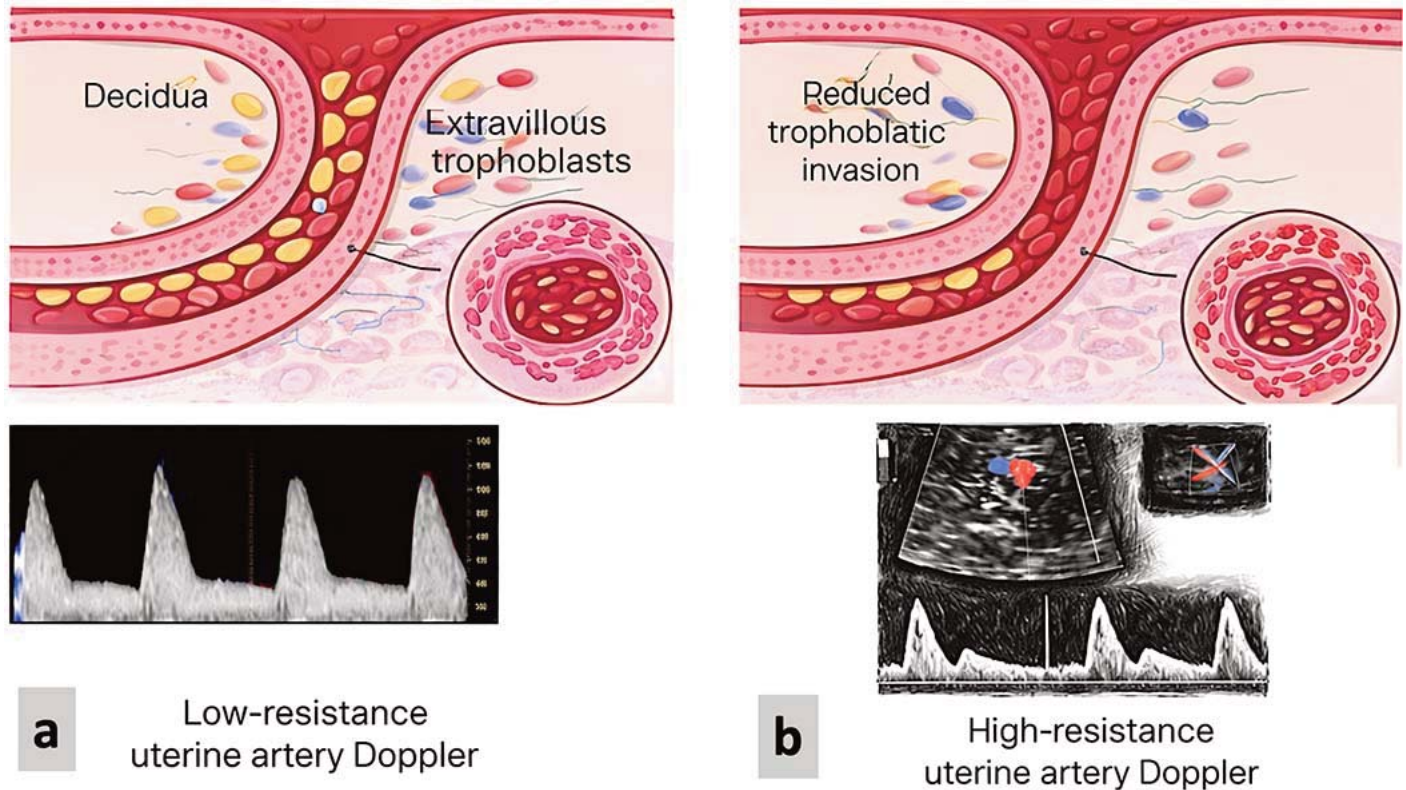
a. In normotensive pregnancies, adequate trophoblastic invasion in the spiral arteries, decidual biopsy, vascular imaging, and Doppler findings. b. In preeclampsia, inadequate trophoblastic invasion in the spiral arteries, decidual biopsy, vascular imaging, and Doppler findings.
